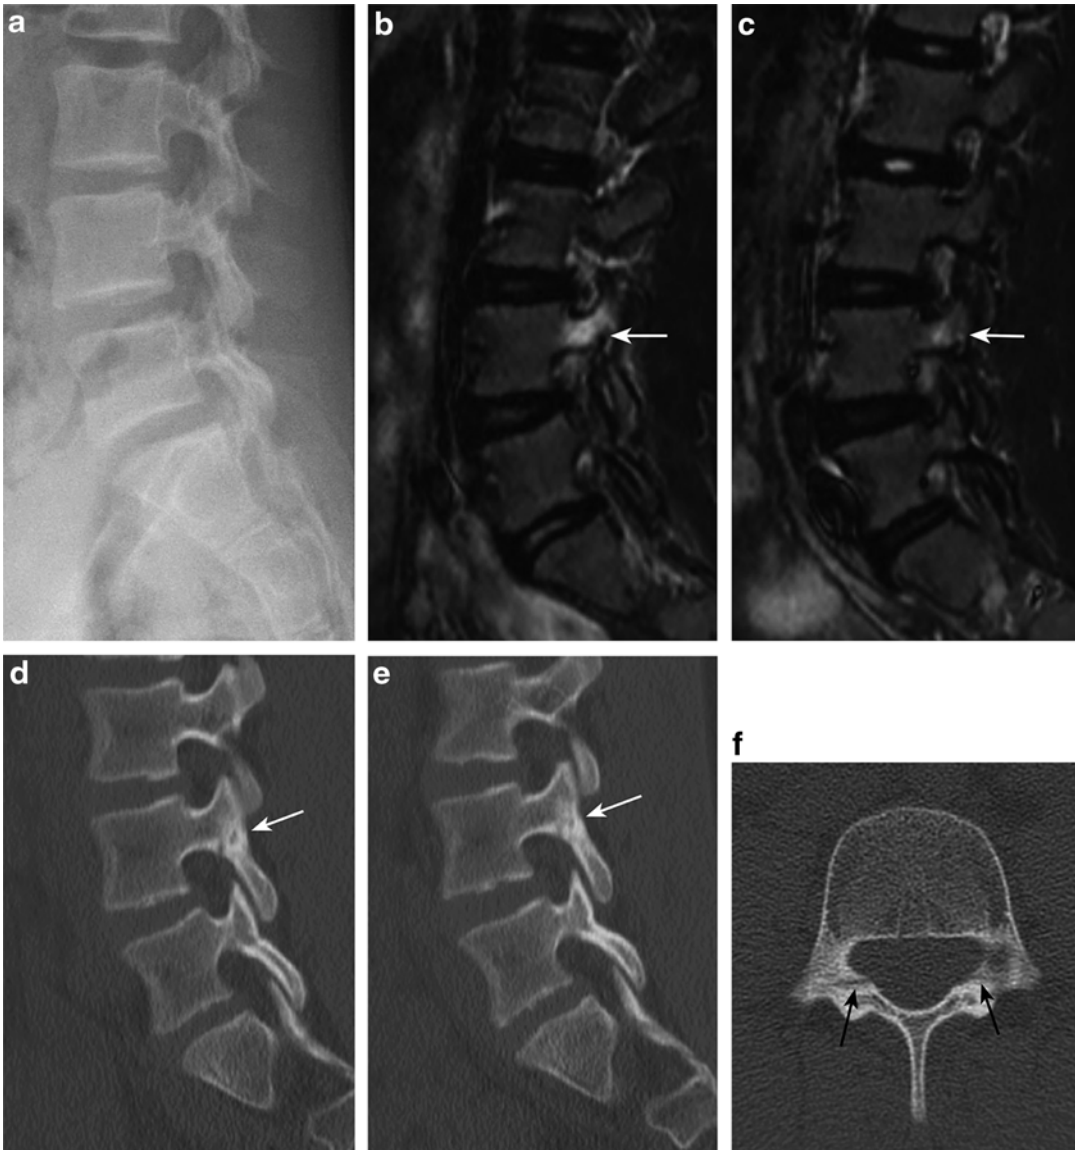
Incomplete bilateral spondylolysis at L4. (a) Lateral lumbosacral spine radiograph appears normal. Sagittal MRI STIR images demonstrate edema in the pedicles of L4, greater on the right (b) than on the left (c). Sagittal reformatted CT images demonstrate lucencies
